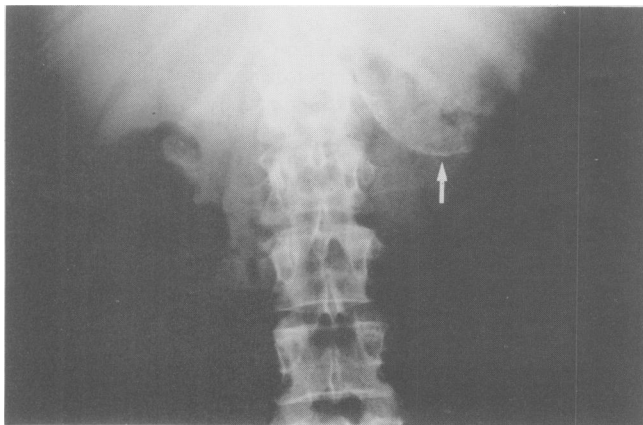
Plain film of the upper abdomen (case 2). A ring-shaped calcification (arrow) is visible in the left upper quadrant (cf. Fig. 3).
